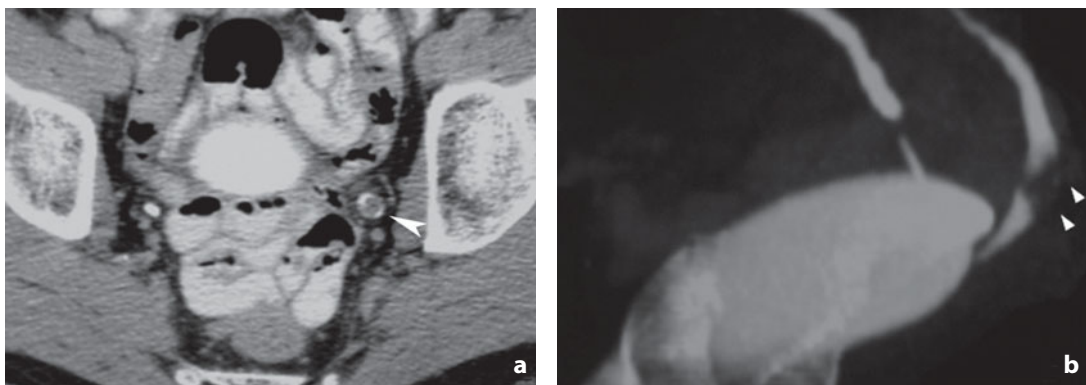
Computed tomography. Distal ureteric tumor. Examination performed in the excretory phase. a Nonobstructive filling defect is discernible in the left ureteric lumen (arrowhead). b MIP reconstruction confirms the filling defect in a urographic-like image
